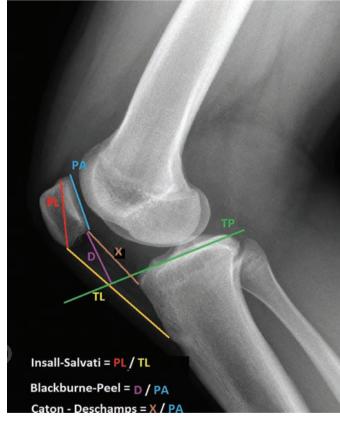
PL: Maximum patella length. TL: patella tendon length. PA: patella articular surface. TP: tibial plateau line. D: Shortest distance between the patella articular surface and the tangential line of the tibial plateau. The Insall–Salvati ratio is PL/TL, the traditional number used is <1.2 (0.8–1.2) with patella being <0.8 and patella alta is >1.2. The Blackburne–Peel ratio is measured on a lateral radiograph with 30° of flexion. It is a measure of patella height taking the patella articular surface (PA) divided by the distance between the horizontal line at the level of the tibial plateau and the inferior aspect of the patella alta being a ratio of >1.0. Caton–Deschamps index is measured by X/PA. A ratio >1.3 is highly suggestive of patella alta
